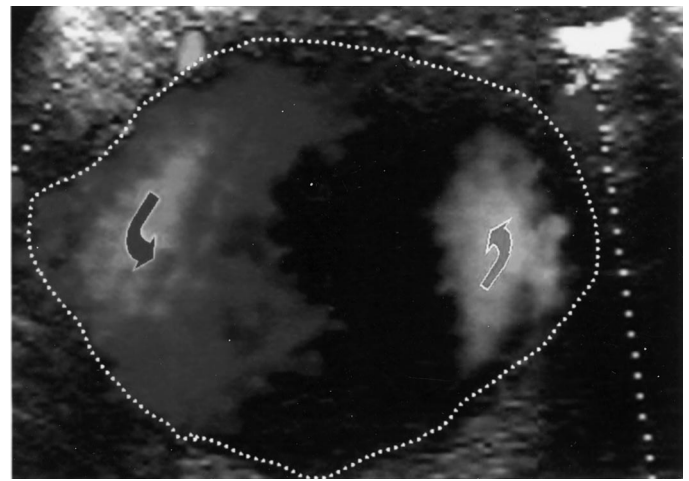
Color Doppler ultrasound (US) scan reveals typical to-and-fro blood flow pattern (*curved arrows*) within the lumen of the pseudoaneurysm (*dotted line* is the lumen of the pseudoaneurysm).
